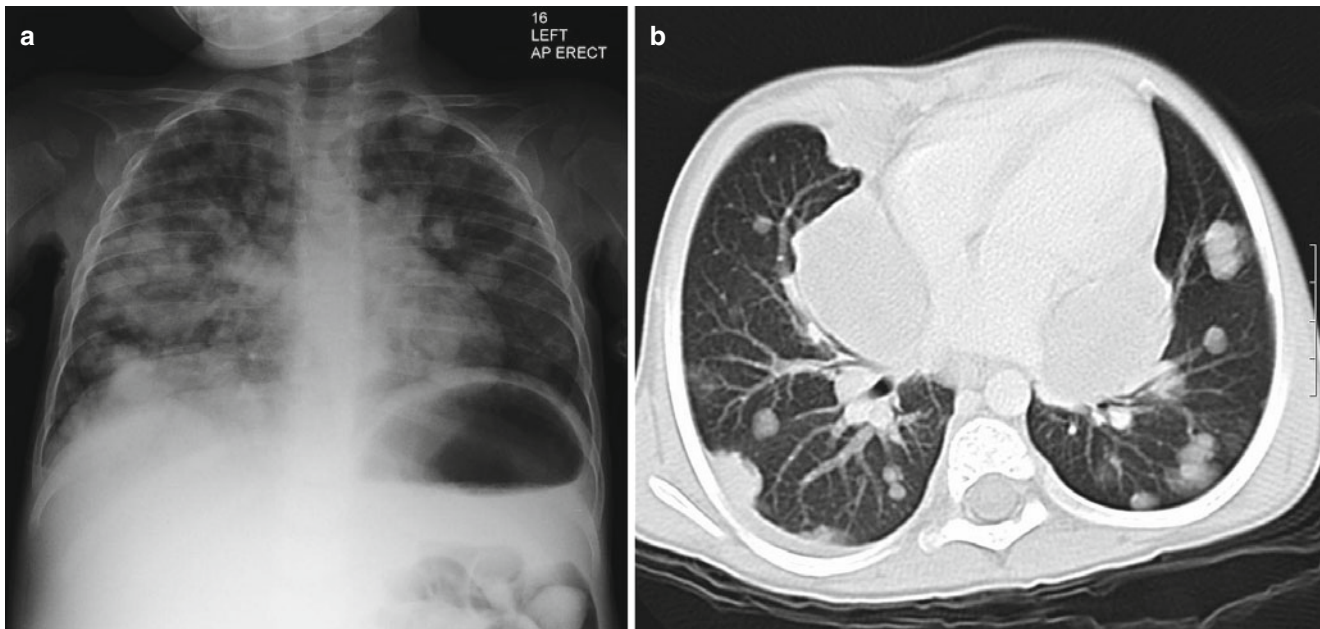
Lung metastases in Wilms' tumor. (a) Chest X-ray showing extensive lung metastases. (b) Lung metastases are best demonstrated on chest CT with dedicated lung window settings
